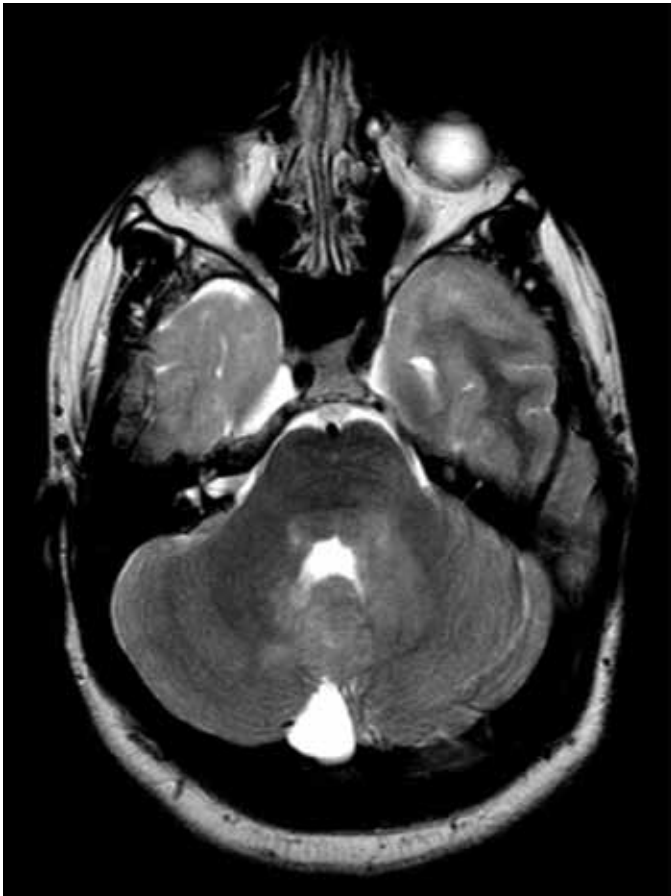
T2-weighted brain MRI: Axial view showing characteristic NF changes of cerebellum and brainstem.
